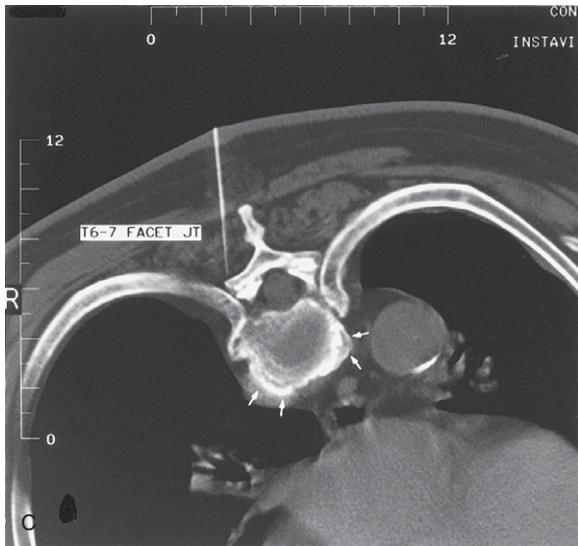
Cont'd (C) Thoracic spine CT scan at the T6–7 zygapophysial 'facet' level showing needle placement for the facet block injection. R = right side of patient. Note the marginal osteophyte formation on the vertebral body (small white arrows). The dural tube shows an abnormally narrowed configuration behind both the T6 and T7 vertebral bodies but the cause is not evident and there is generous fat around the dural tube within the bony spinal canal.
